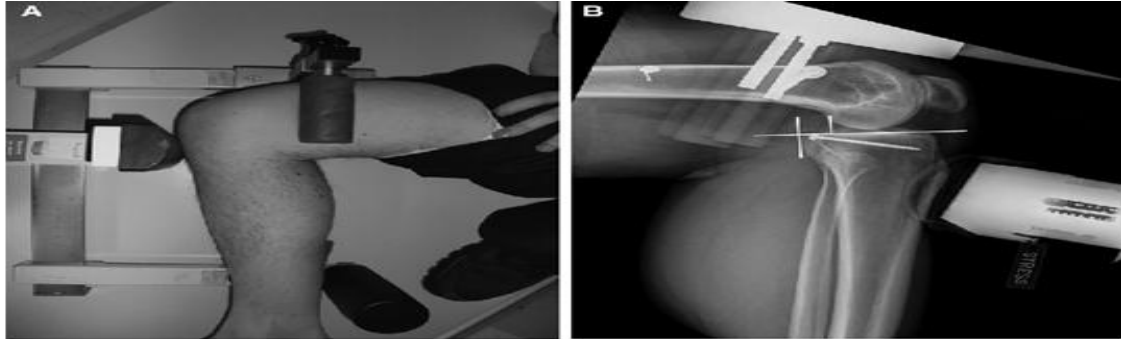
The posterior stress radiography of the knee. (A) The patient is positioned supine with the knee flexed to approximately 70°–90°, stabilized in a mechanical stress device while a posterior force is applied to the proximal tibia. (B) The corresponding lateral radiograph shows posterior tibial translation relative to the femur, allowing objective assessment of posterior cruciate ligament (PCL) integrity.
